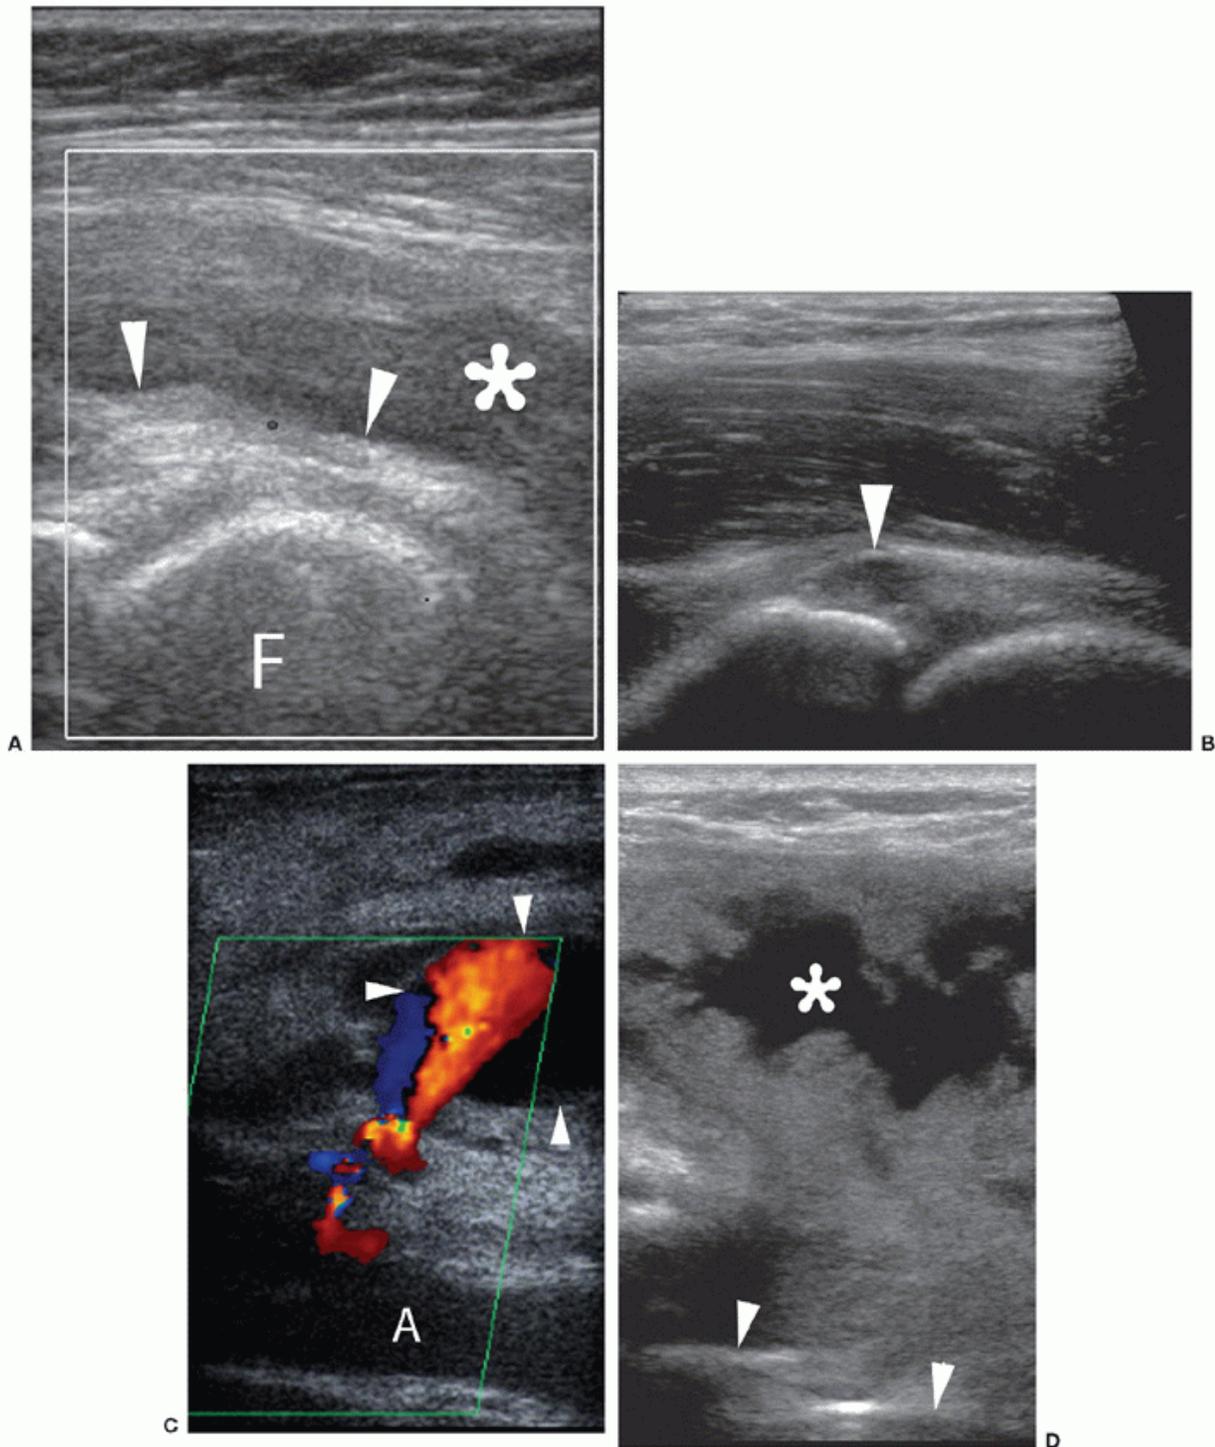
Mimics of hips effusion. A: Longitudinal sonogram shows femoral head (F) and psoas bursa (asterisk). Arrowheads mark the hyperechoic capsule deep to the fluid. B: Longitudinal sonogram shows anechoic paralabral cyst (arrowhead) at the acetabular rim. C: Longitudinal sonogram shows femoral artery false aneurysm (arrowheads). Color Doppler shows communication with the underlying artery (A) and turbulent internal flow. D: Longitudinal sonogram shows extra-articular collection (asterisk) separate from the deeper femoral neck (arrowheads) and effusion.
